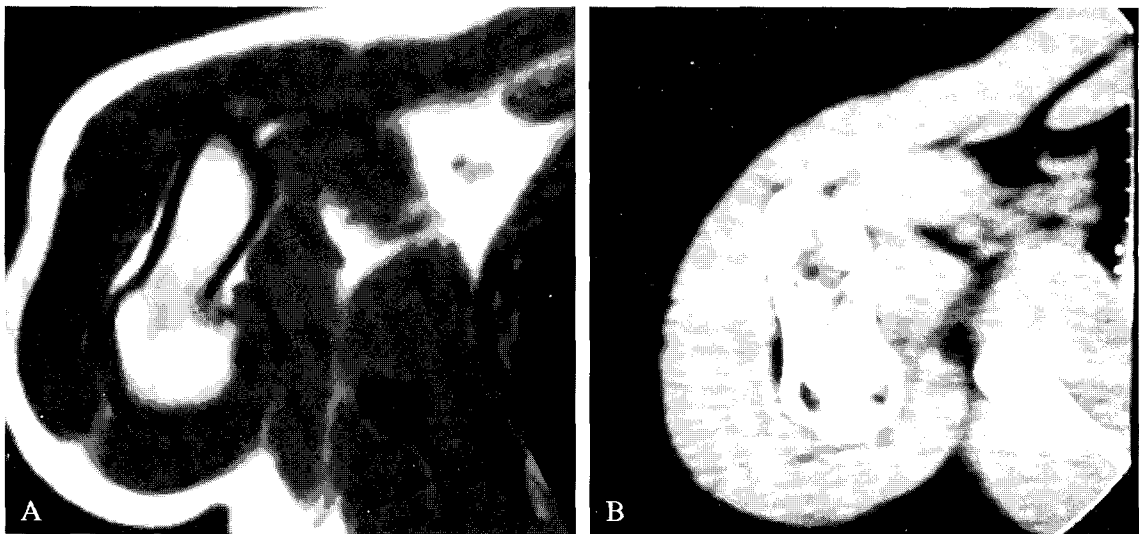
MRI, T2 weigh, (A) and CT scanning (B) confirm the posterior-medial site of the osteochondroma in the proximal humeral diaphysis. The osteochondroma is in partial contact with the axillary nerve and posterior humeral circumflex artery; there is no contact with the radial nerve and profunda brachii artery. Moreover MRI and CT Scanning rule out invasion of the soft tissues and confirm the benign bone tumor.
